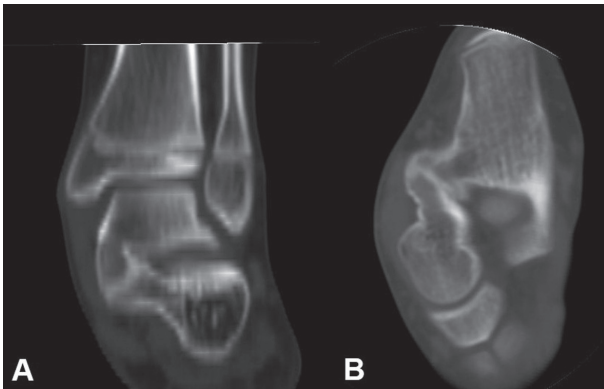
Multidetector computed tomography with MPR reconstruction in axial and coronal plane of medial calcaneal astragalus synostosis
